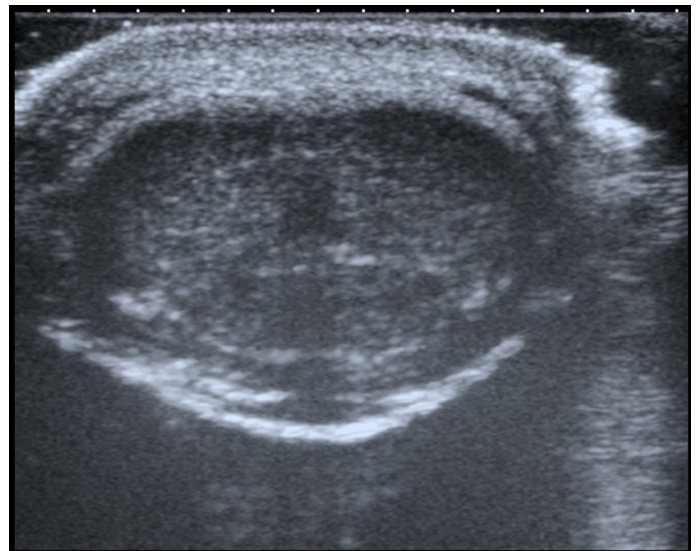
No tunical plaque or fibrosis was visible around 2 cavernous bodies and corpus spongiosum with gray-scale ultrasound imaging.
